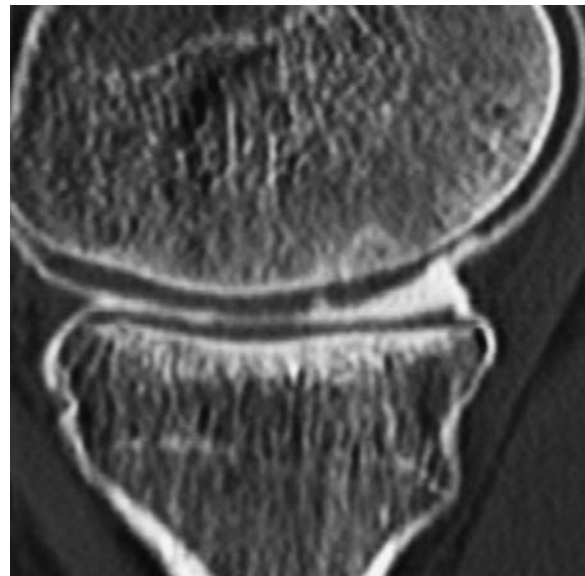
Cartilage defect. Sagittal CT arthrography of the knee. Cartilage lesion starting with a full thickness fissure anteriorly, followed by a grade II region which progresses to grade III posteriorly
